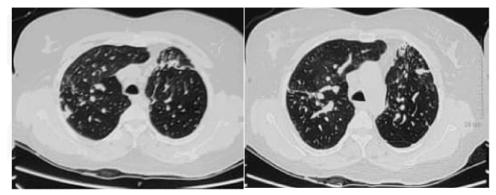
A HRCT chest demonstrated fibroatelectatic changes (arrows) in bilateral upper lobes (left>right)
